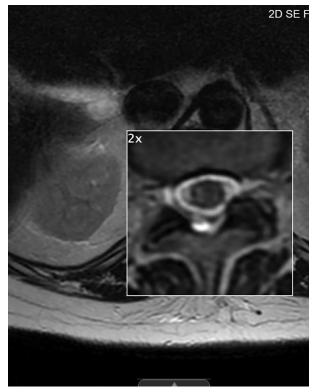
An MRI showing T2 hyperintensity within the conus medullaris.
